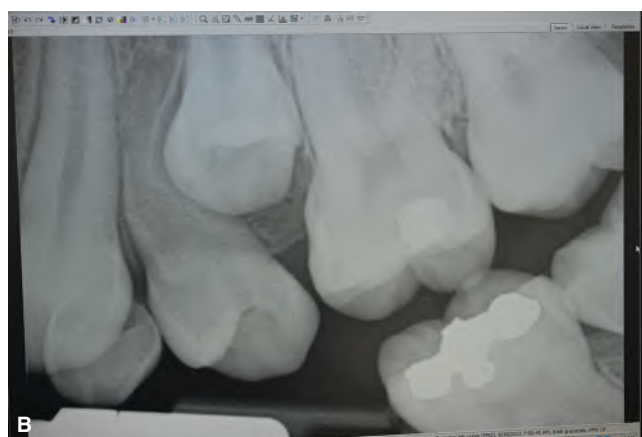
A. Clinical picture of a child in the mixed dentition period after early extraction of the primary maxillary right second molar, and mesial drift of the permanent first molar. B. Periapical radiograph of an adolescent after early extraction of the primary maxillary left second molar and impaction of the succedaneous tooth due to mesial drift of the permanent first and second molars and distal drift of the first premolar. (38-6A, courtesy of Dr. Shaul Yehezkel, Los Angeles, CA, U.S.A.)
